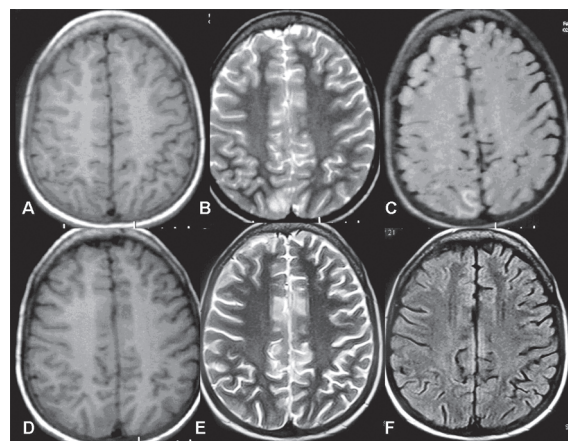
Initial axial T1-weighted (A), T2-weighted (B), and FLAIR (C) and follow-up axial T1-weighted (D), T2-weighted (E), and axial FLAIR (F) MRI show a focal cortical edema and hyperintensity on axial FLAIR T2-weighted images in the right occipital region (A-C). The lesion had disappeared on follow-up MRI (D-F).
